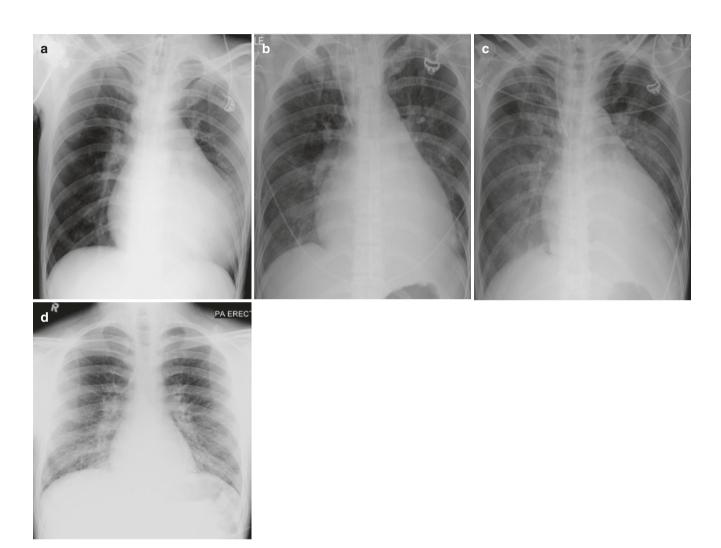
Radiographic progression of hydrostatic pulmonary edema. (a) AP bedside chest radiograph obtained in a patient with acute myocardial infarction demonstrates redistribution of pulmonary vessels with upper lobe diversion upon admission to ICU. (b) Next day radiograph demonstrates features of interstitial edema in the form of indistinctness of pulmonary vessels and bilateral perihilar haziness. (c) Progression to bilateral central consolidation and small pleural effusions representing alveolar edema is seen on the radiograph obtained on
